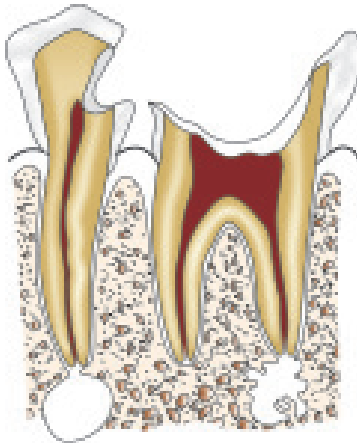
Two nonvital pulps and periapical inflammation results due to severe demineralization and cavitation reaching the pulp chamber and canal
